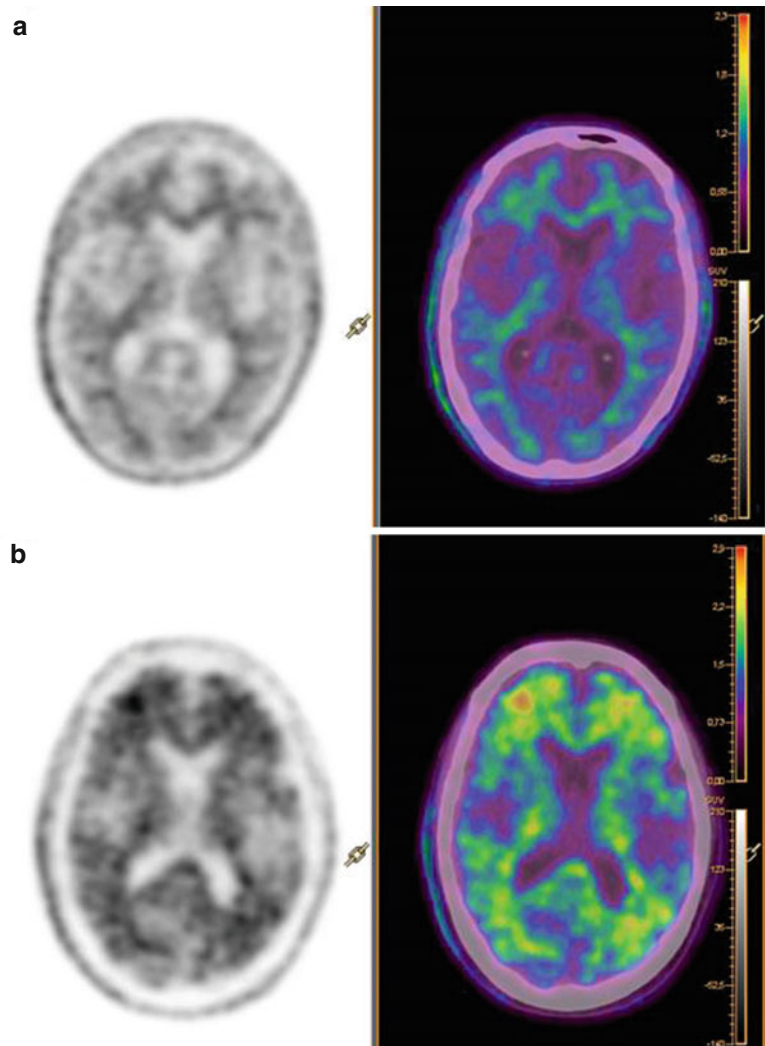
Images of 18F-florbetapir PET (*left*) and PET-CT (*right*) in patient with DLB without cortical A β deposition (a) and in DLB patient with high cortical deposition (b)
